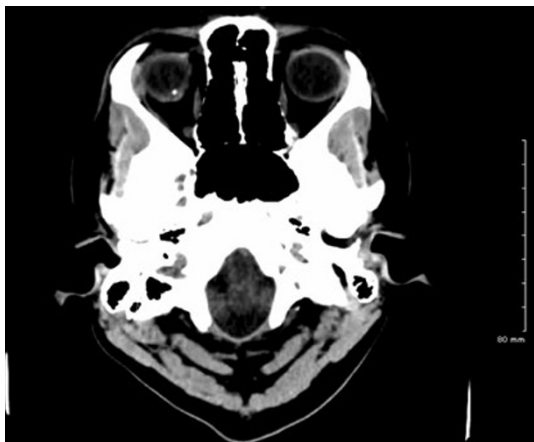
CT scan demonstrating calcified optic nerve head drusen in the right eye
